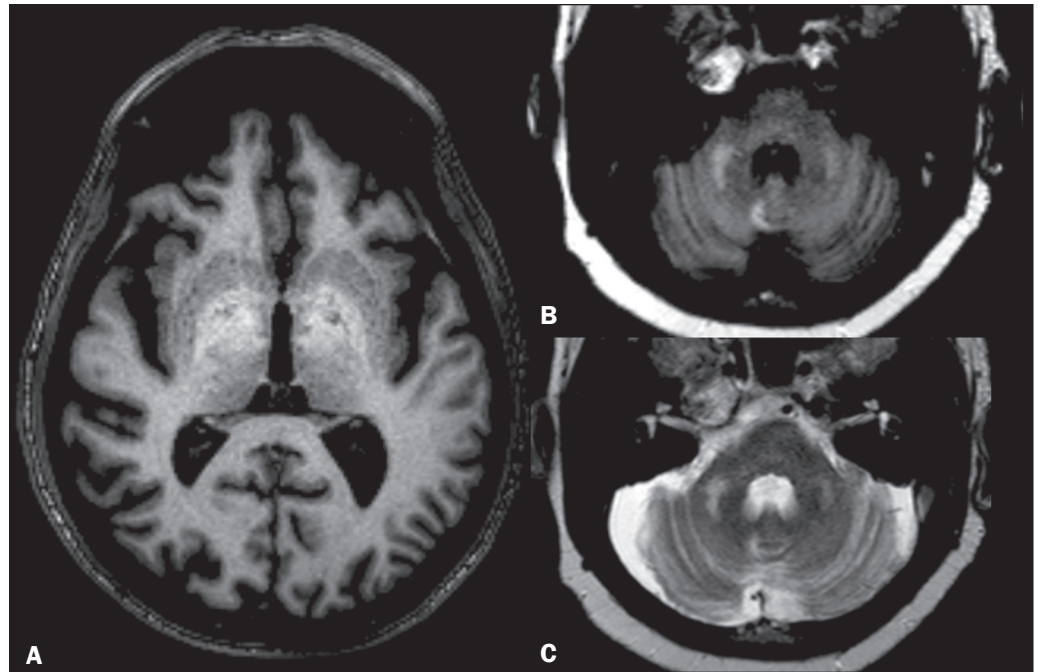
HE. A: Axial T1WI showing hyperintensities in the globus pallidus. Axial FLAIR sequence (B) and axial T2WI (C) showing asymmetrical hyperintensities in the MCPs.
